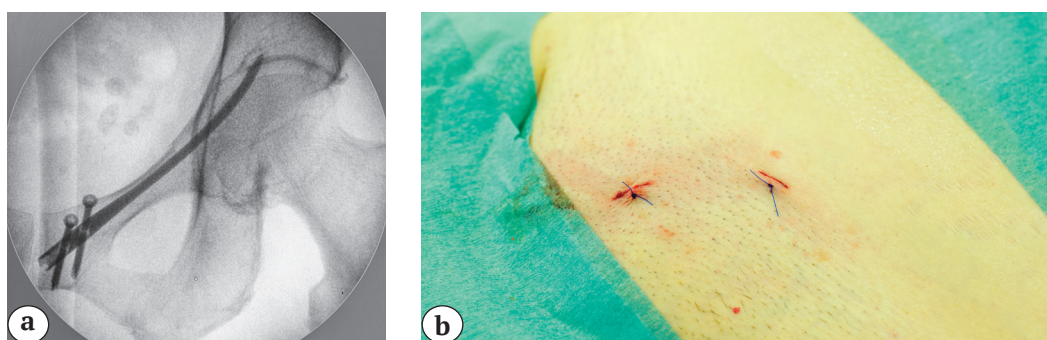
Final X-ray image after fixation of the pubic rami fracture with the interlocking nail (a); postoperative view after osteosynthesis surgical field after wounds closure; surgical field after wounds closure (b)
